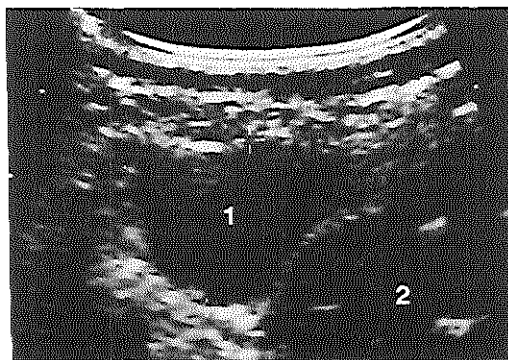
Fluid filled area based on an abscess-cavity adjacent to the pharynx shown by ultrasound (longitudinal view; case 1).
